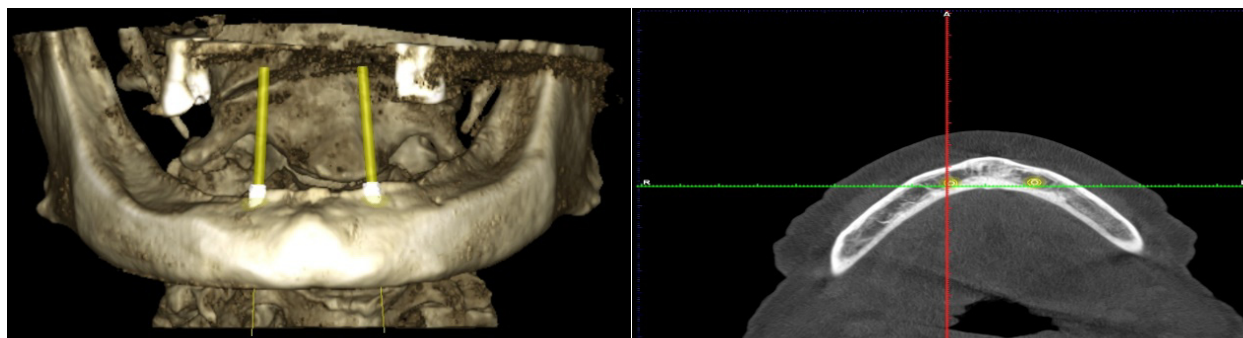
CBCT radiographic images of an edentulous mandible with virtually positioned implants.
